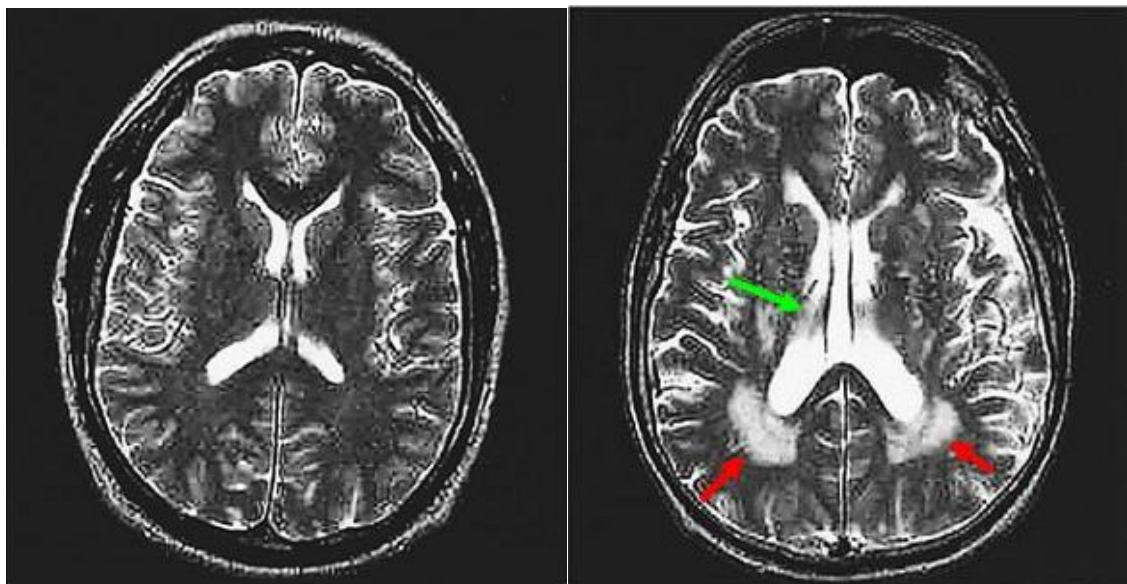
MRI showing enlarged ventricles (green arrows) and white matter hyperintensities (red arrows) in a 79-year-old man (right) which correspond to white matter rarefaction. On the left, a 24-year old male (normal). (Modified from Raz, 2001)
